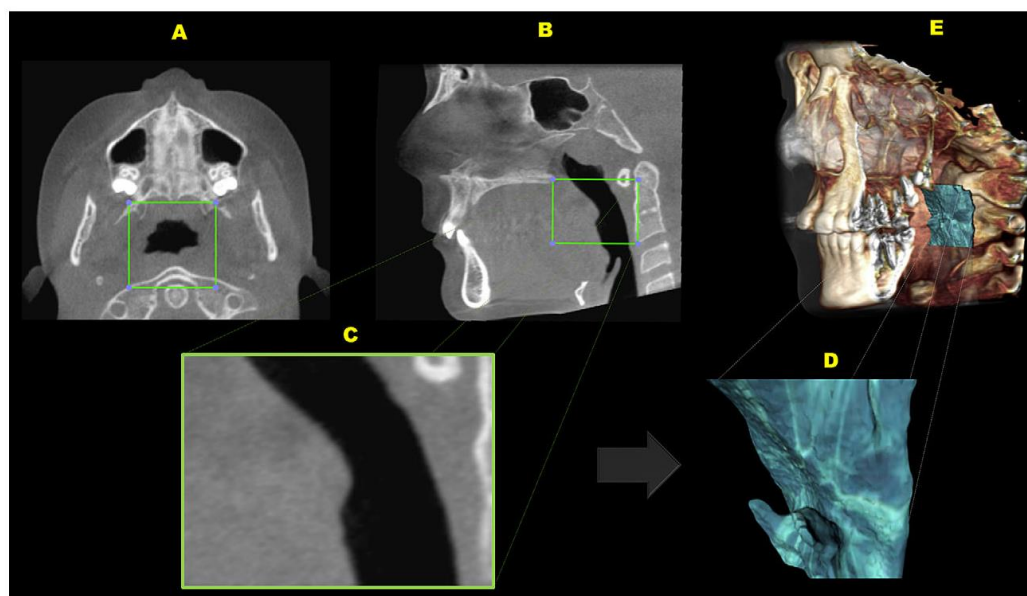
A and B, CBCT images after head reorientation with OsiriX software, in the axial and sagittal views, respectively, with the oropharynx's region of interest delimited (green box) in the axial and sagittal images; C, 3D volume exported as a new DICOM file; D, from this new volume, the segmentation was performed and the oropharynx's 3D model obtained for volume analysis; E, location of the oropharynx's region of interest in the patient's head.
